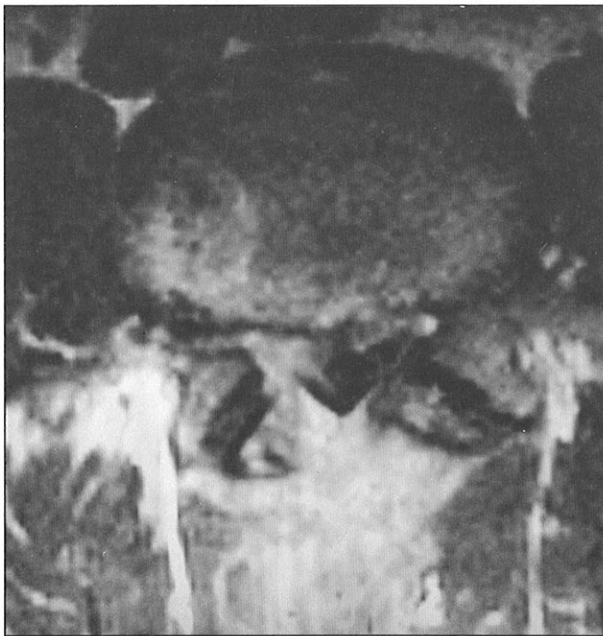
Axial T1-weighted image showing the loss of epidural fat planes and the presence of a lesion on the right side of the spinal canal.
